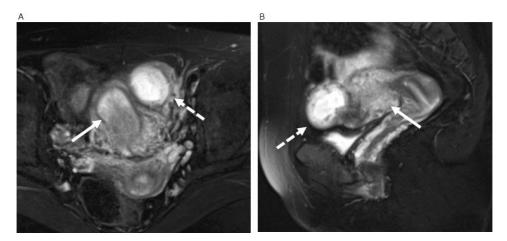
MRI T2-weighted image. A) Horizontal cross-section. B) Sagittal section. Solid arrow; Uterus. Dotted arrow; rudimentary uterine horn pregnancy (gestational sac). Mass with a gestational sac and live fetus was seen on the left side of the uterus. Connection between the mass and the uterus with no endometrial continuity
